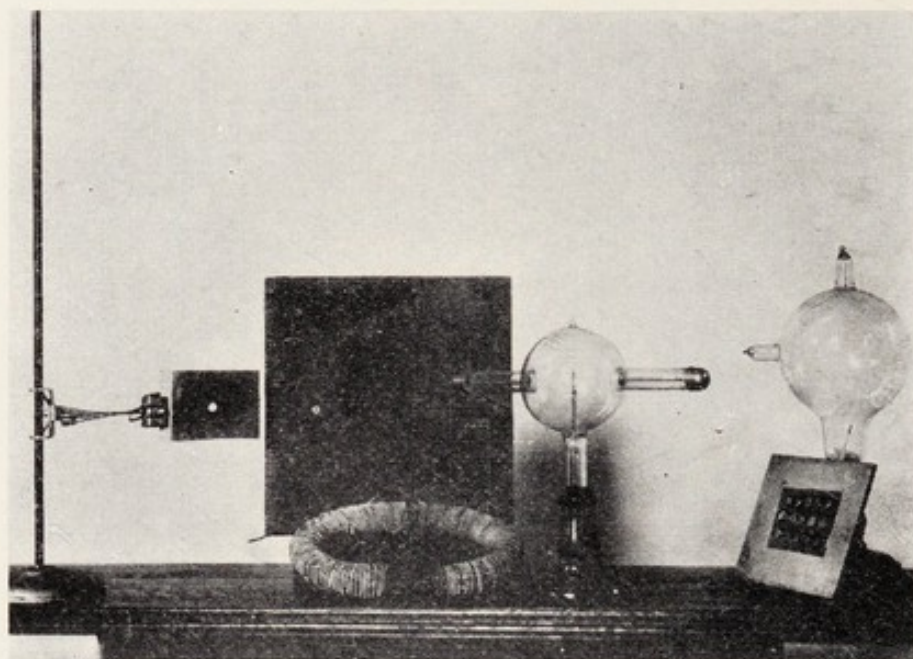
Tubes, targets, screens and magnets used by Roentgen in his early work.
